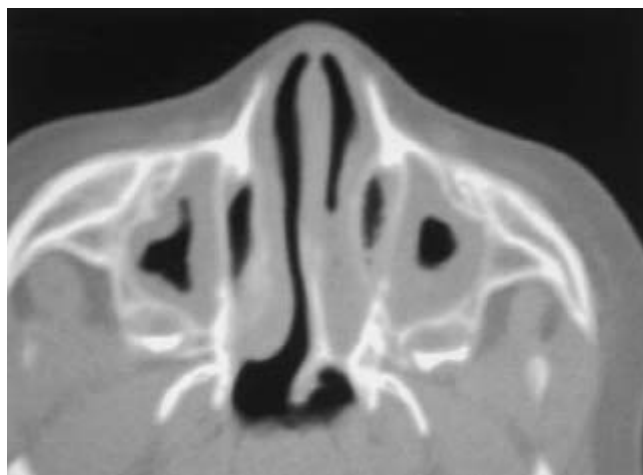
CT Scan, horizontal plane: Right unilateral choanal atresia.
